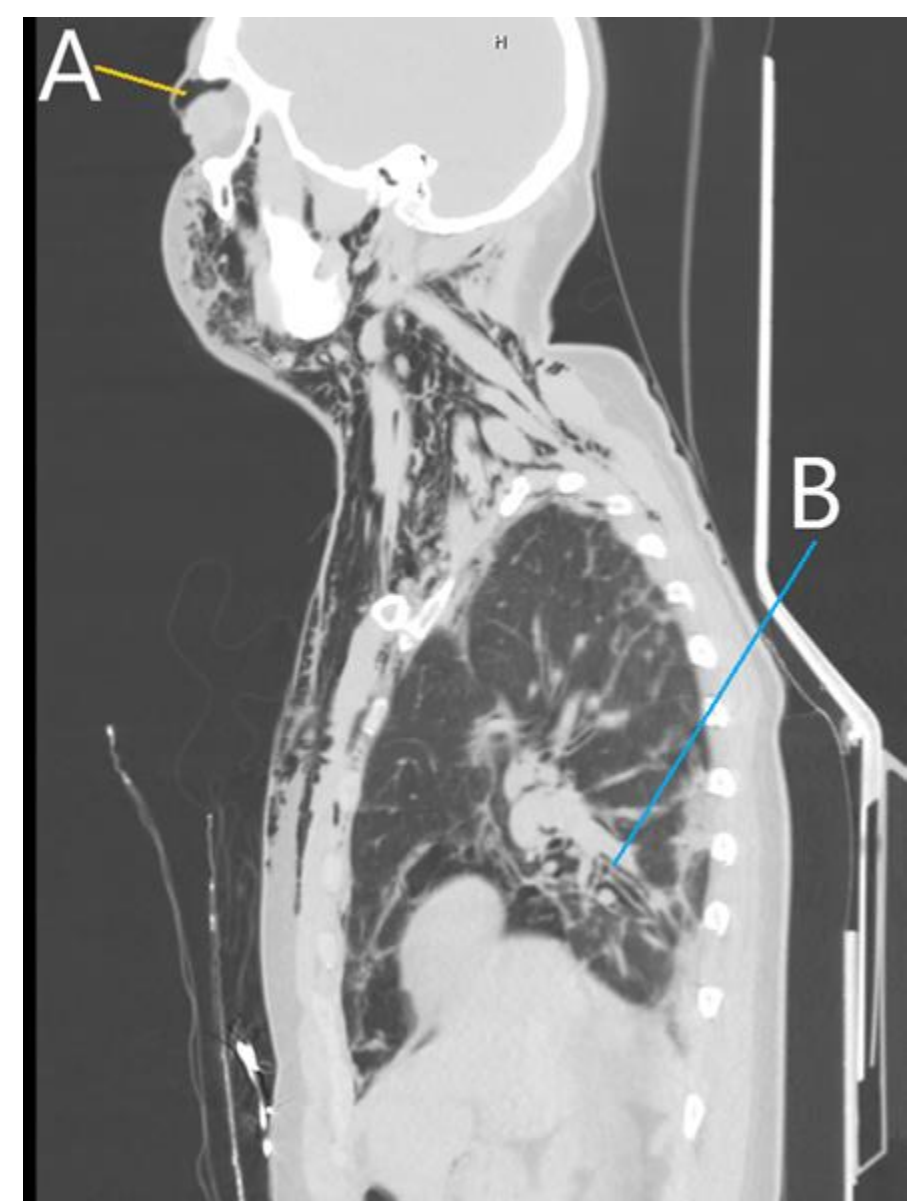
CT Torso revealed air around the orbits (A), as well as air around the left hilar region, around the pulmonary artery (B).
